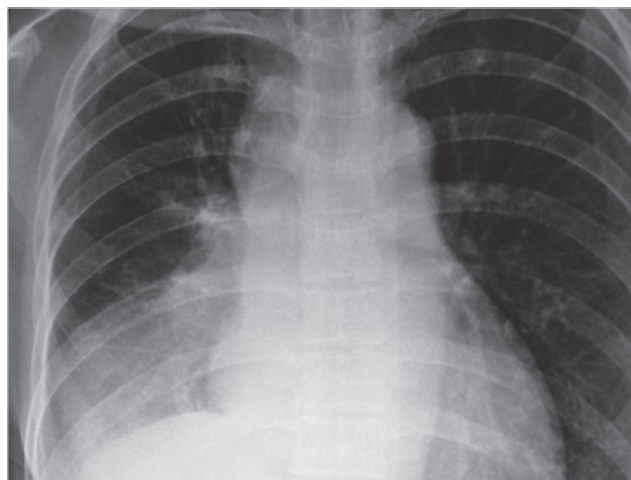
A follow-up simple chest X-ray showing normal pulmonary vasculature without residual hernia.
